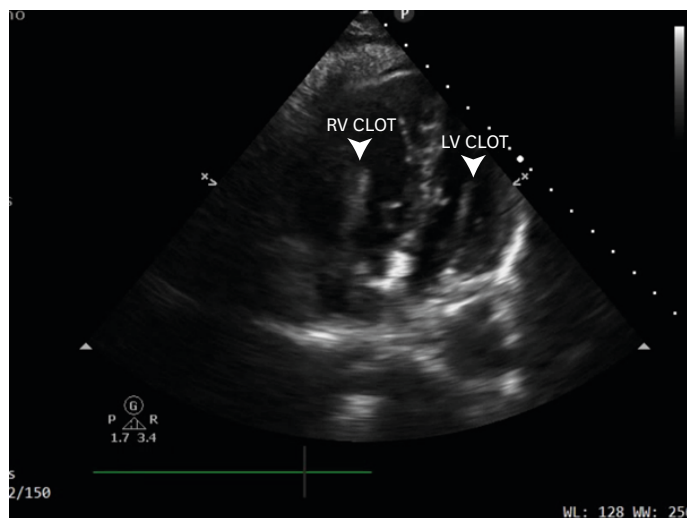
Apical 4 chamber view showing an embolic clot that protruded into the RV and LV. LV: left ventricle, RV: right ventricle.
